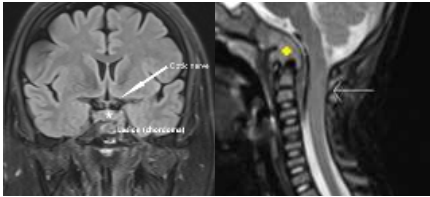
(right/First) : T2 FLAIR coronal MRI sequence image showing proximity to lesion with optic nerve without abutment or involvement
